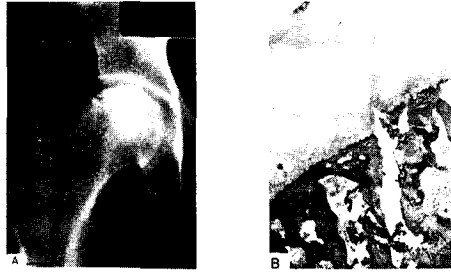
A, Radiograph of the right femoral head in a 28-year-old male with bilateral nontraumatic necrosis of the femoral head demonstrates minimal collapse at the weight-bearing area opposite the lateral margin of the acetabulum. Increased density extends from the foveal region to inferior neck.
